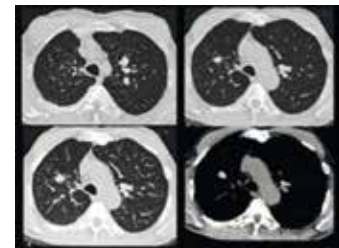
Non enhanced CT of the chest displayed at the level of the upper lobes
